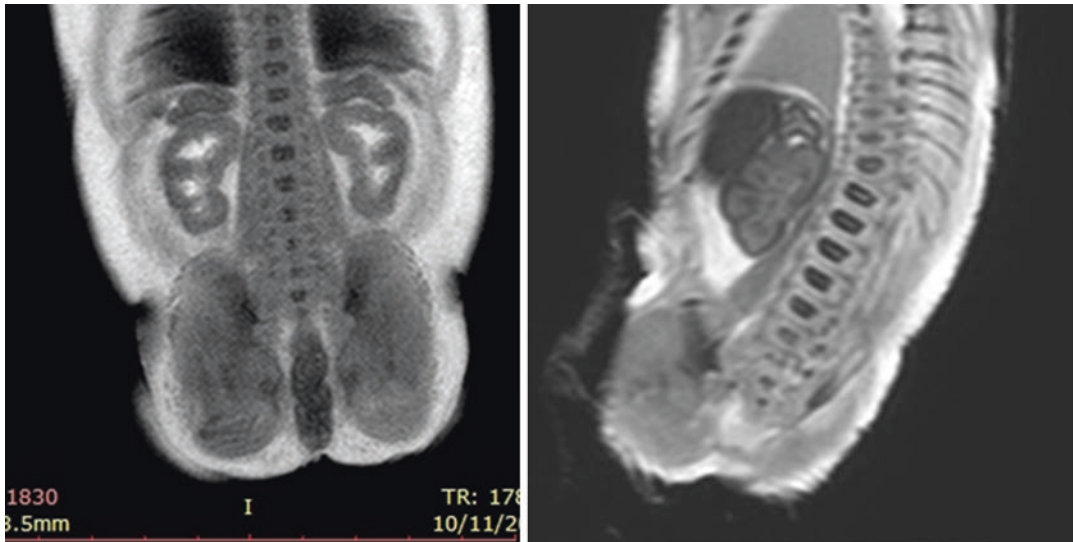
Post-mortem MRI coronal T2w TSE in two different fetuses shows normal kidney with its lobes and the adrenal glands
